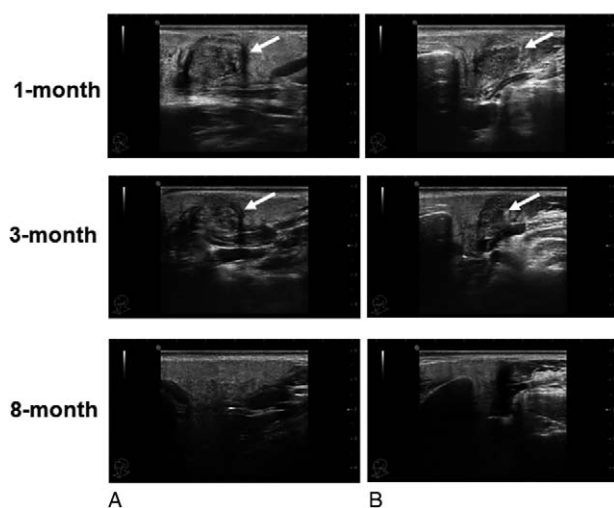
Post-ablation 1-month, 3-month, and 8-month ultrasound evaluation. The tumor (arrow) sizes were $1.72 \times 1.47 \times 0.95$ cm (reduction ratio, 53%), $1.43 \times 0.79 \times 0.79$ cm (reduction ratio, 82%), and 0 cm. (A) Cross-section images; (B) longitudinal section images.
